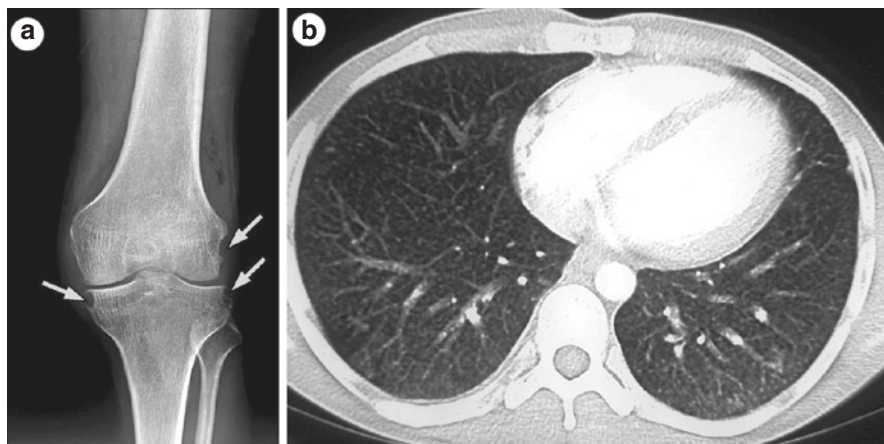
The Phemister triad: Reproduced with permissions from The Lancet Volume 391 Issue 10,135 (May 2018) Arghya Chattopadhyay, MD, Prof Aman Sharma, MD, Prof Kirti Gupta, MD, Prof Sanjay Jain. Anteroposterior x-ray left of knee (standing) showing multiple marginal erosions (arrows), periarticular osteopenia, and reduced joint space (a) and high-resolution chest CT showing subtle miliary mottling (b)*
